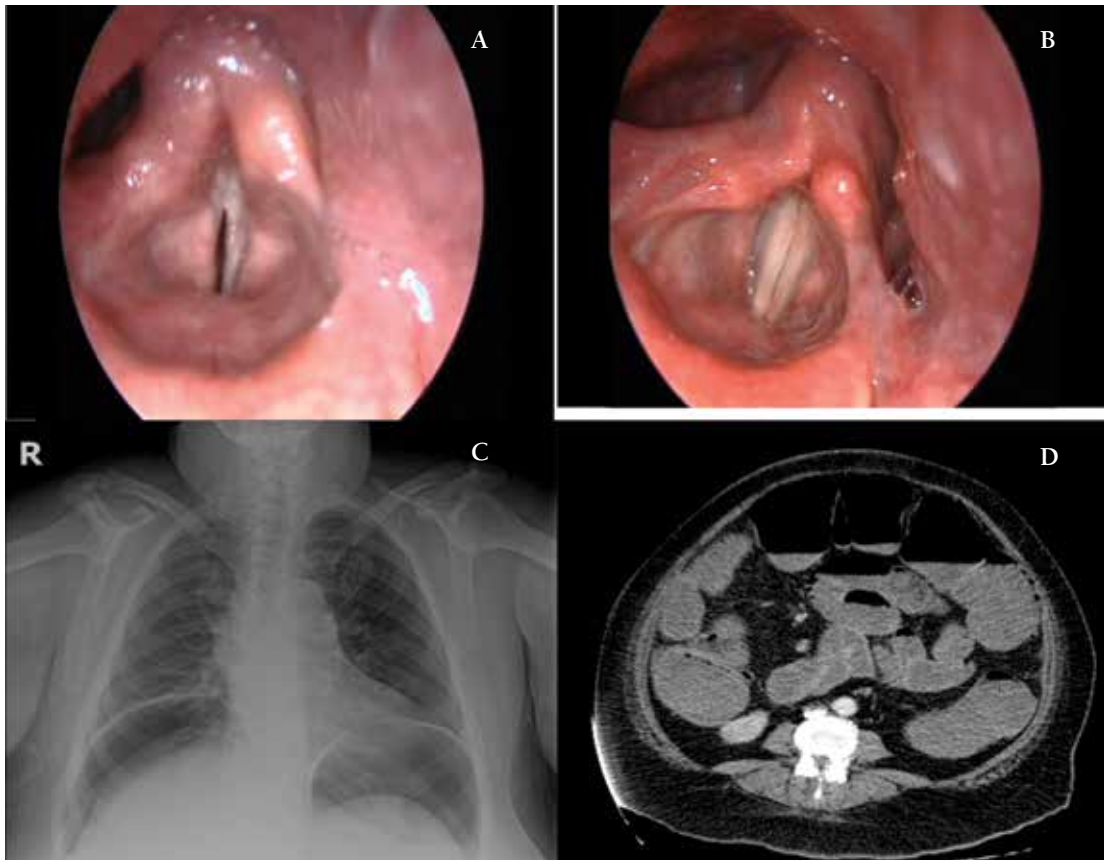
Videolaryngoscopy reveals immobile left vocal cord (A) and normal moving vocal cords (B) in case 1. Plain X-ray shows free air beneath the diaphragm (C) and abdominal CT shows dilated loops with intestinal pneumonitis (D) in case 2.
